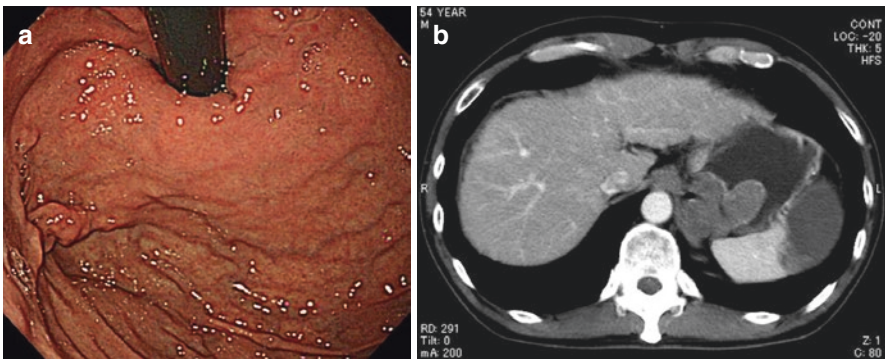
(a) CT 1 week after TJO showing that the gastric varices are completely obliterated by the thrombi. (b) Endoscopic picture 3 months after PSE and TJO showing that the gastric varices are eradicated
